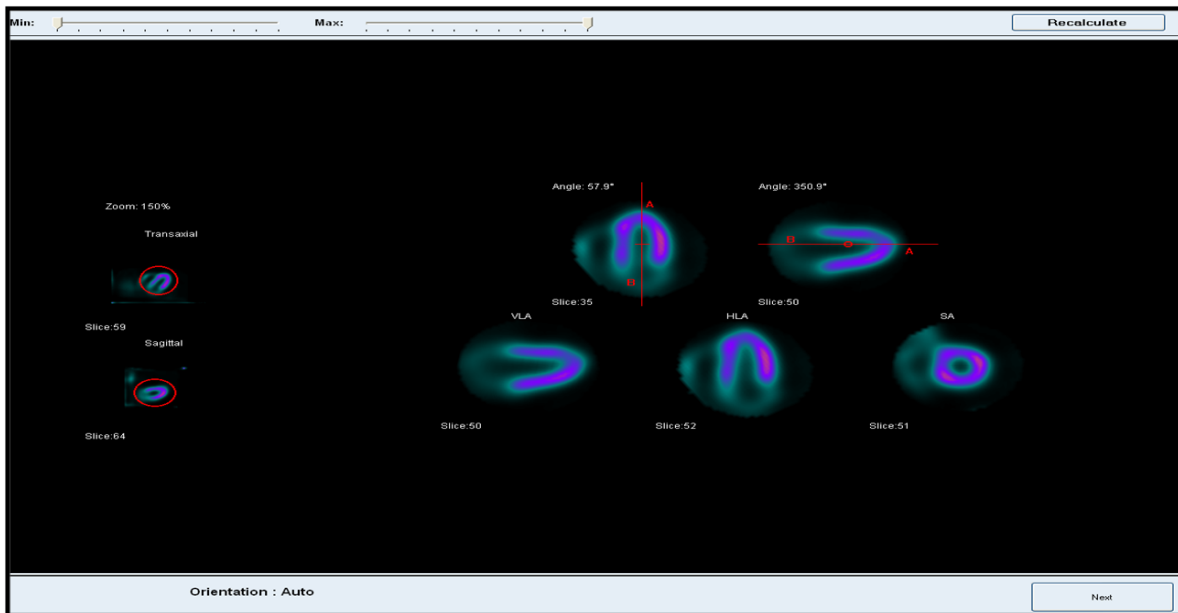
Sub-interface of the D-SPECT reconstruction software. This interface allows the visualization of the reconstructed myocardium in the three standard views, as well as the manual re-orientation of the myocardial axes.
